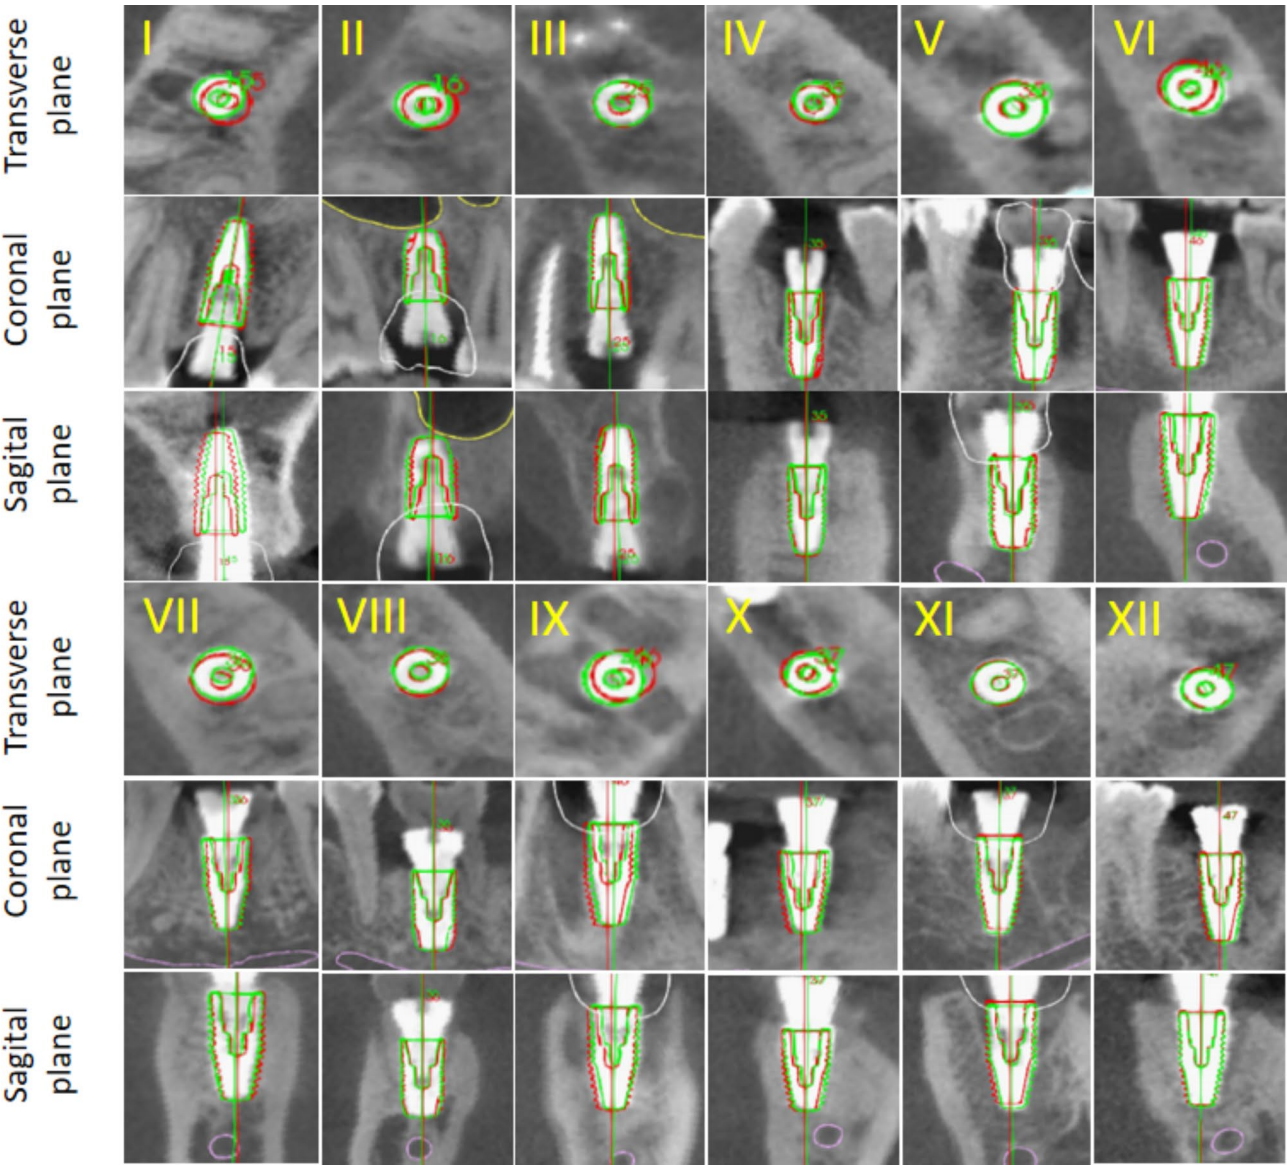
CBCT fusion images of planned and placed implants for each case. Planned implants are outlined by red and placed implants by green. *CBCT* cone-beam computed tomography
